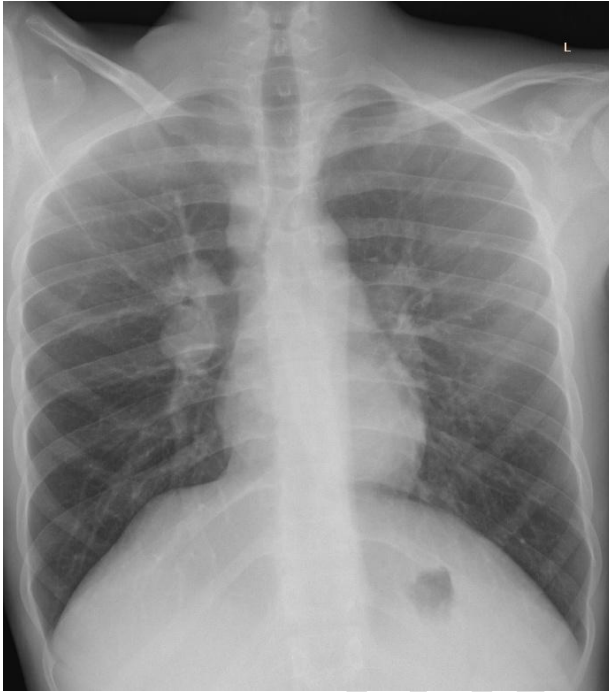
Posterior-Anterior X-ray shows right paratracheal & right para-hilar lymphadenopathy with right upper lobe reticular infiltrates suggestive of lung infection with cryptococcal pneumonitis
